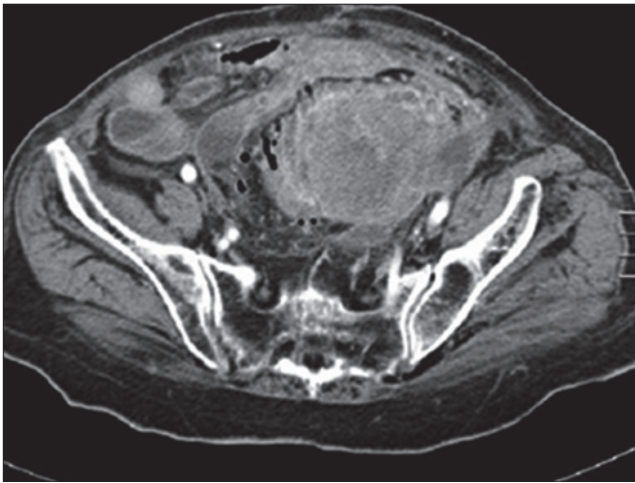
Abdominal computed tomography of a patient with carcinosarcoma of the rectum.
